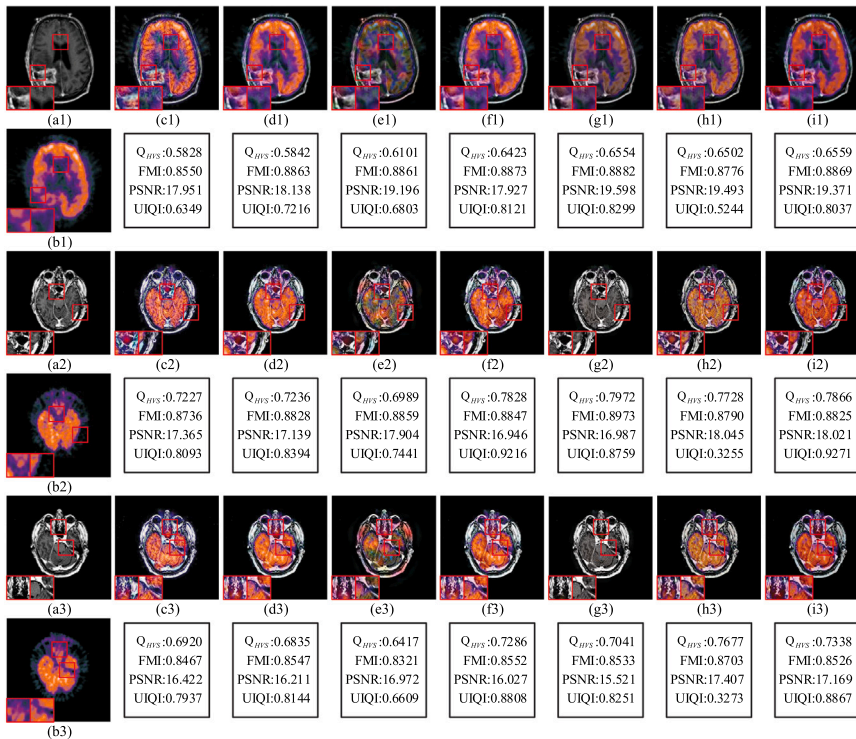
The visual result of various fusion methods on MRI and PET images. The proposed method obtains more competitive results than other methods. Please refer to the main text for more detailed descriptions. The fused images obtained: (a1-a3) MRT; (b1-b3) PET; (c1-c3) LLF-IOI; (d1-d3) NSST-PAPCNN; (e1-e3) NSCT-PCDC; (f1-f3) NSCT-RPCNN; (g1-g3) GFF; (h1-h3) IFCNN and (i1-i3) DRCL.
